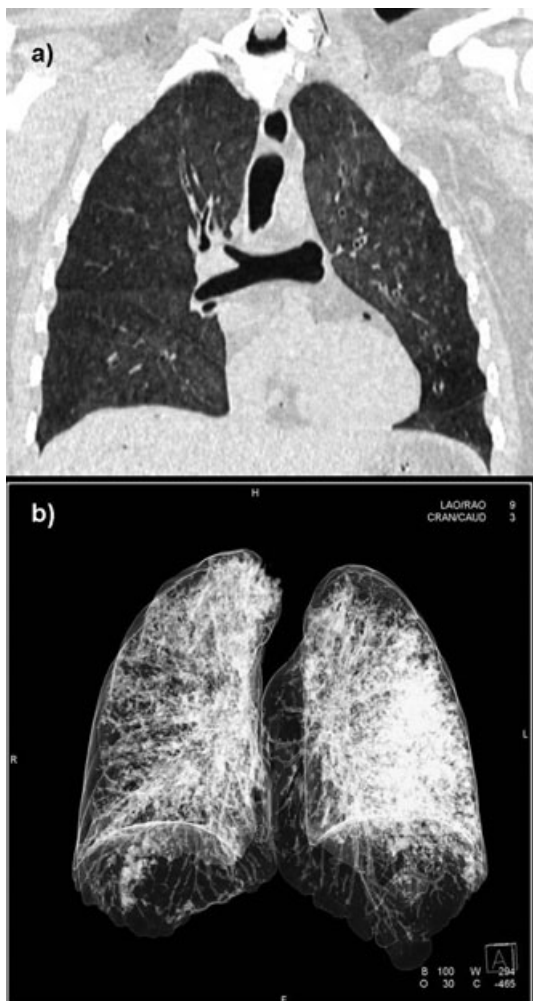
The distribution and severity of aspiration abnormalities in case n. 15 assessed by CT imaging. (a) 2D and (b) 3D volume-rendering images show multiple nodular ground-glass opacities distributed homogeneously in both lungs. In this case, blood aspiration was determined to be the primary cause of death by the radiologist.
